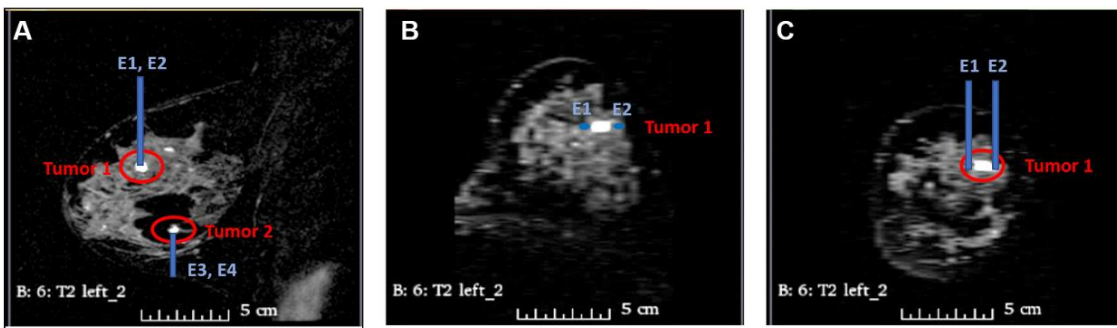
Insertion of four needle electrodes (E1, E2, E3 and E4) for treating two breast carcinomas segmented from MRI images. (A) Electrode insertion parallel to the sagittal plane, (B) normal to the axial plane, and (C) electrode insertion represented on the coronal plane.
